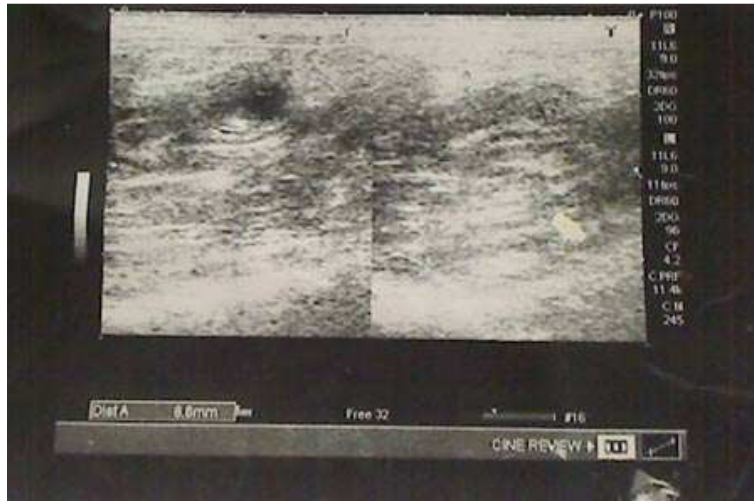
High resolution Ultrasonography of right iliac fossa showing lobulated thick walled hypoechoic blind loop.
